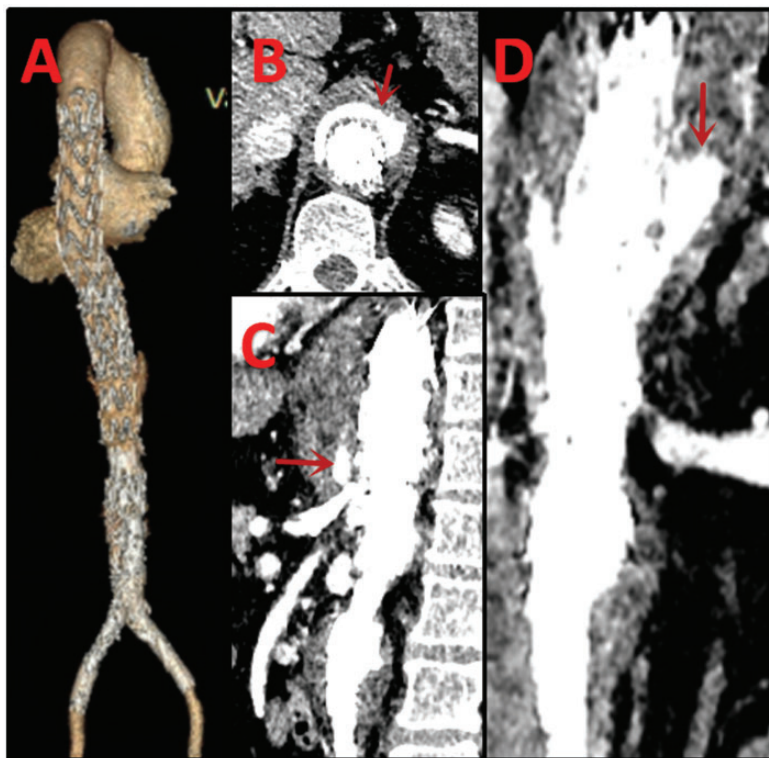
Postoperative computed tomographic angiography images at 1 week after the final surgical stage in a 66-year-old male with a thoracoabdominal aortic aneurysm (Crawford type III): (A) three-dimensional image of the aorta and iliac artery; (B–D) endoleak around the graft in axial, sagittal, and coronal images, respectively. The arrows show the endoleak at the section of CA. The colour version of this figure is available at: <http://imr.sagepub.com>.
